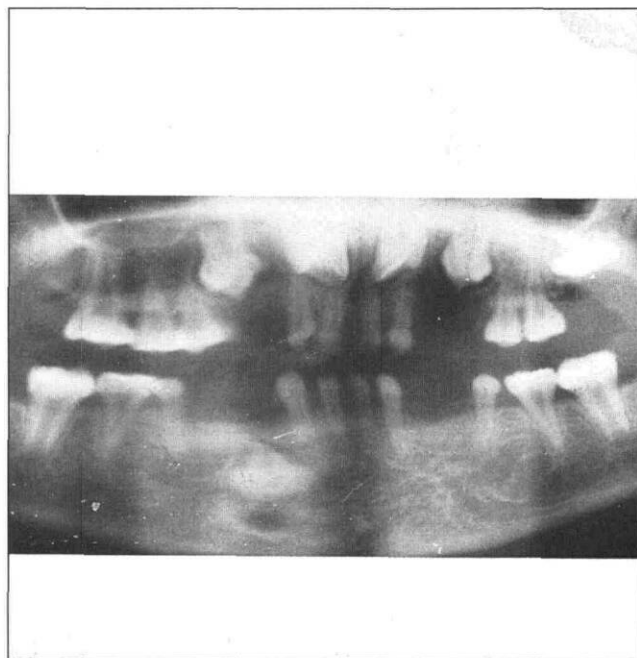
Panoramic radiograph of Case 2. Notice the single-rooted primary and permanent molars and the multiple missing teeth.
